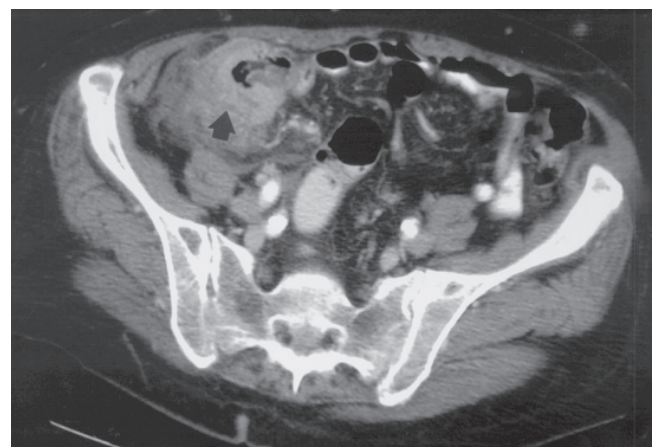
Computed tomographic scan shows inflammation in the pericecal area (arrow) and cecal edema, which could represent cecal diverticulitis. Because the appendix is not clearly visualized, appendicitis cannot be ruled out.
